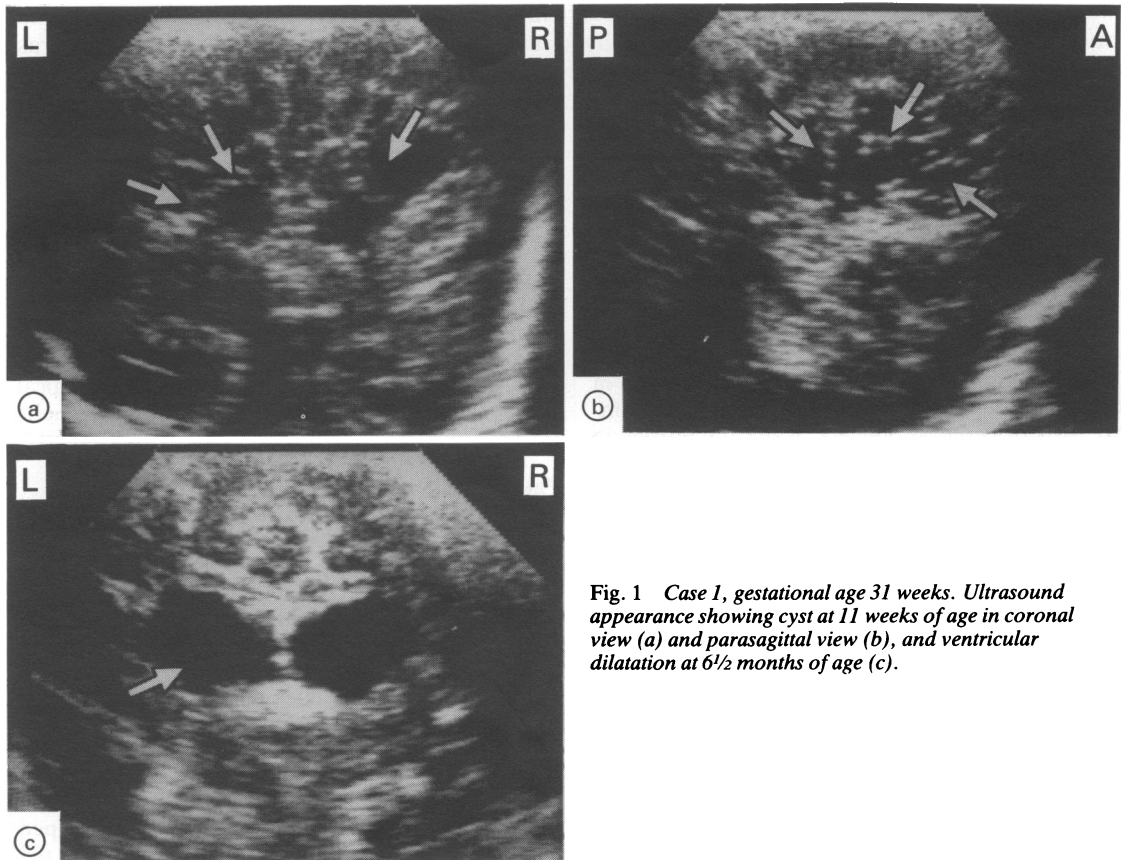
Case 1, gestational age 31 weeks. Ultrasound appearance showing cyst at 11 weeks of age in coronal view (a) and parasagittal view (b), and ventricular dilatation at 6½ months of age (c).
